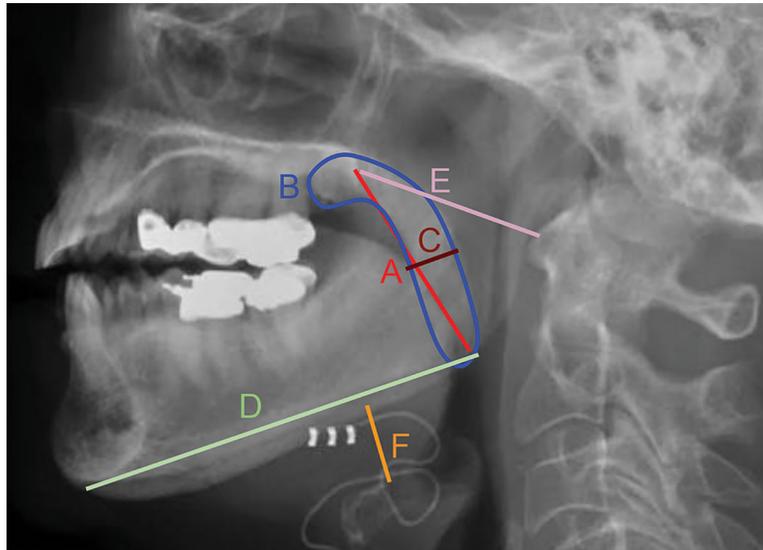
Lateral x-ray of implanted hypoglossal nerve stimulation. Colored lines represent cephalometric measurements. (A-C) Soft palate length, area, and thickness, respectively. (D) Mandibular length. (E) Posterior nasal spine to C1 vertebra distance. (F) Mandibular plane to hyoid distance.
